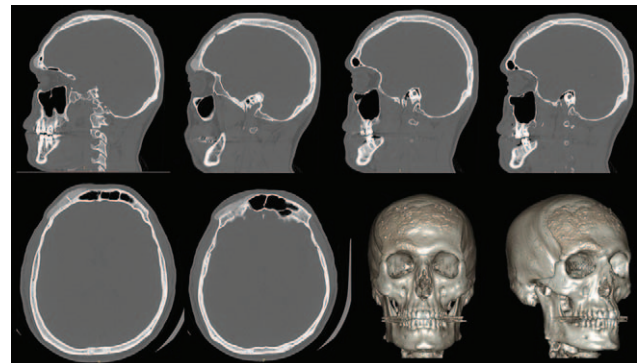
Computed tomography scans 10 months postoperatively showed a marked ossification in the defect areas.
